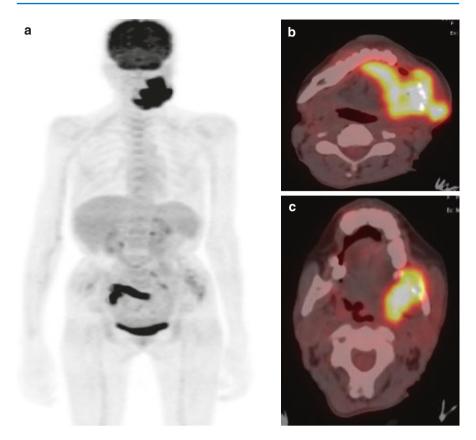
The use of FDG PET CT in a patient with metastatic squamous cell carcinoma in head and neck cancer with an unknown primary. Primary tumor detected in the right pyriform sinus (*arrows*). (a) PET image showing right level II cervical lymph node and primary tumour in right hypo pharynx. (b) Transaxial CT Images showing the right level II cervical lymph node. Primary tumour is no obvious. (c) Transaxial PET CT images highlight right level II cervical lymph node and primary tumour in right pyriform sinus (Indicated by *yellow arrow*)
